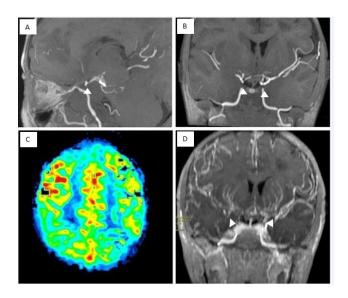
(1A-1D): (A) Magnetic angio-resonance of the skull, (B) Multiplanar parasagittal and coronal reconstruction, sequence T1: decrease in the caliber of perforating thalamus vessels and collateral circulation in the lenticulostriate region of the skull base; (C) MRI perfusion technique: hypo perfused areas in the left frontal and parietal region compared to the right hemisphere; (D) 2D angiographic sequence TOF: decrease in the caliber of internal carotid arteries and neovasculature formation in the supraclinoid region.
